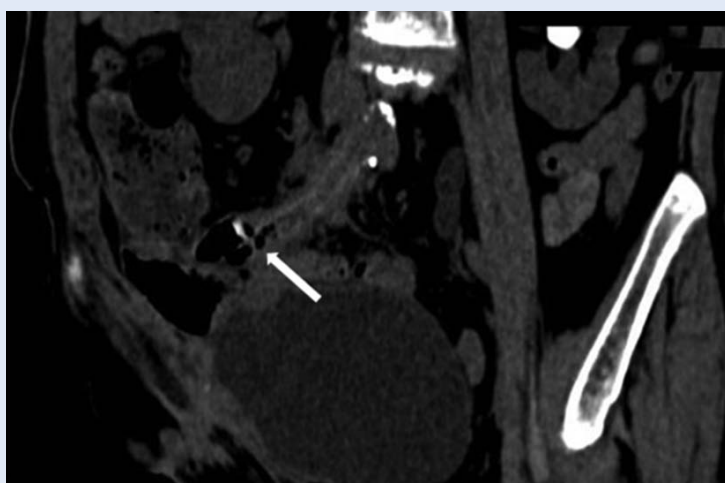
The CT finding of the iliac artery prosthesis-stump protrusion into a small bowel (arrowed)
